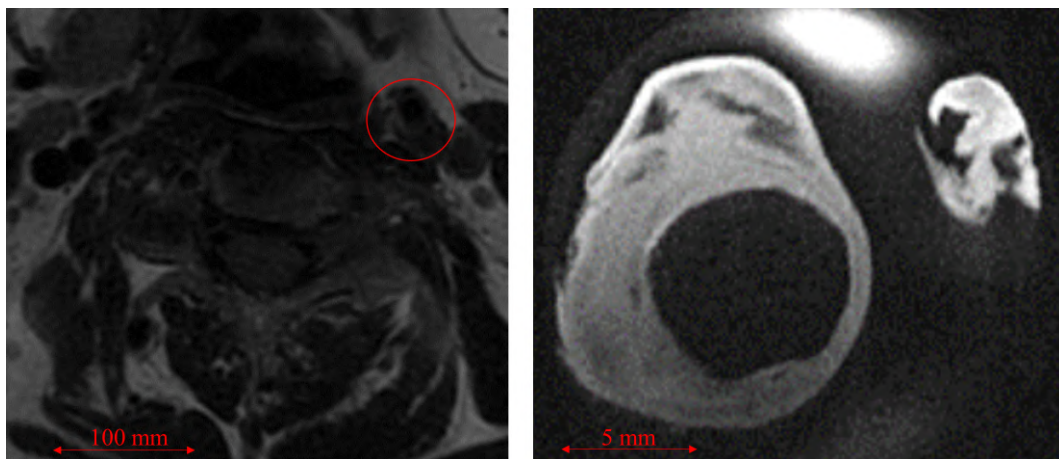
Comparison between *in vivo* MR image acquired at St. Anne's University Hospital Brno (left) with a standard device without the carotid coil and *ex vivo* MR image acquired at Institute of Scientific Instruments in Brno with 9.4 T Bruker BioSpec 94/30 USR device. The region of interest in the left figure shows a location of the carotid artery, which is almost undetectable. It is, therefore, tough or even impossible to use such data for model reconstructions. On the other hand, the right image shows the section of a carotid artery with even more details.
